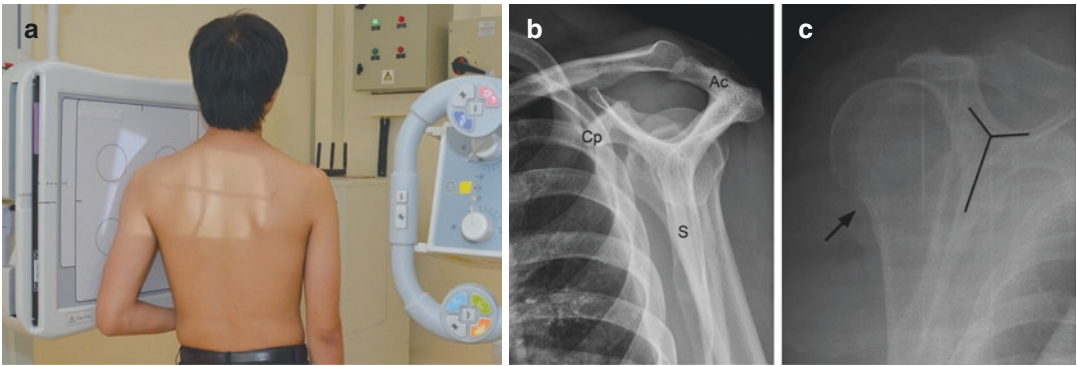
(a) Radiographic positioning for scapular Y-view. (b) Normal scapular Y-view showing coracoid process (Cp), acromial process (Ac), and blade of scapula
